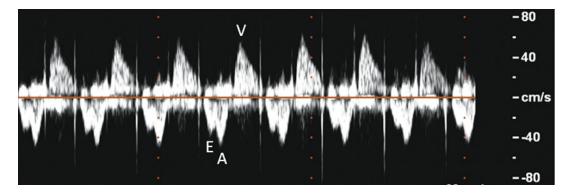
Normal pulsed Doppler image obtained from an apical five-chamber view with the sample volume positioned in the left ventricle to obtain both ventricular inflow and outflow. The flow below the baseline is normal mitral inflow with an e-point (E) and a-point (A).
